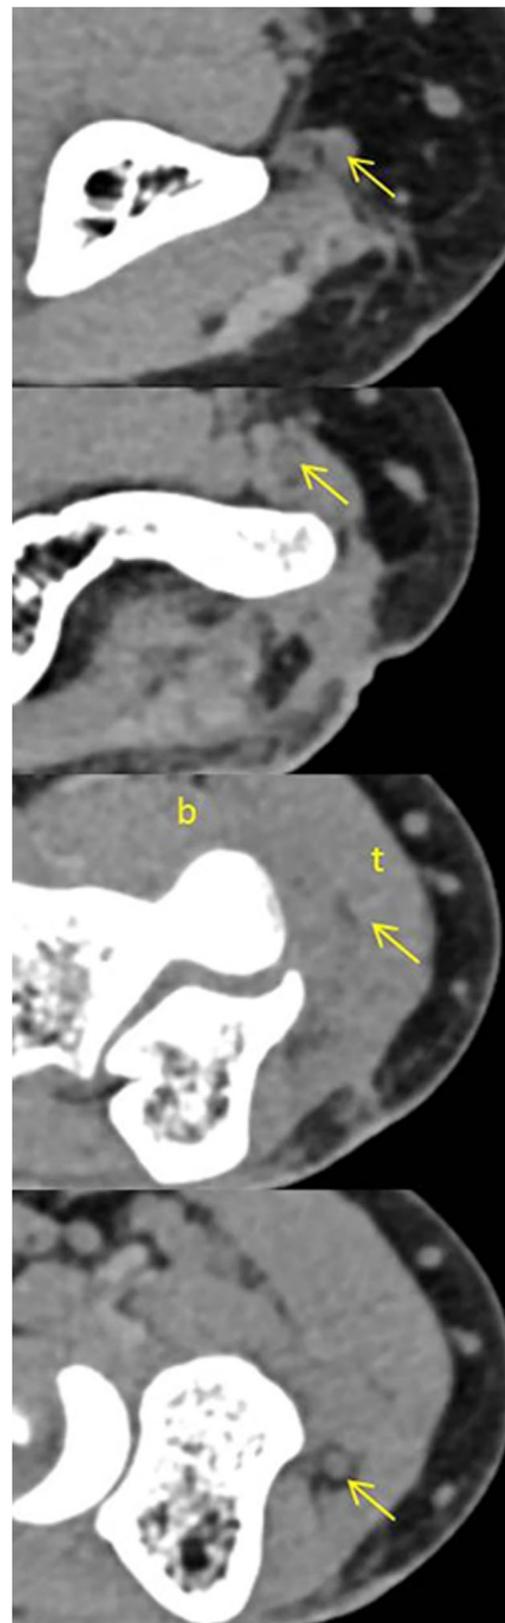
CT images progressing distally (*top to bottom*) demonstrate the ulnar nerve (*yellow arrows*) after submuscular transposition. Small fat surrounding the nerve can often be noted along much of the nerve's course to help in its localization
